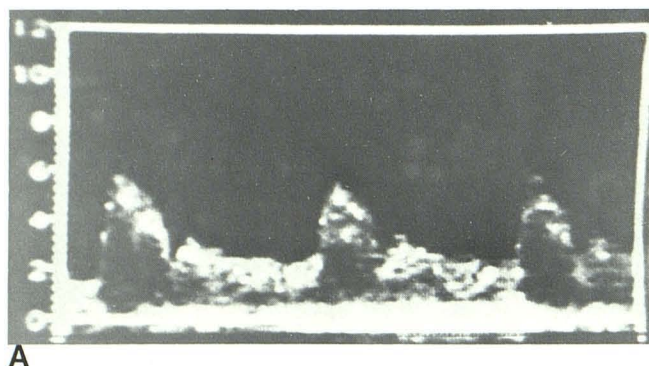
Severe stenosis with relatively normal signals. False-negative diagnosis of stenosis in 76-year-old man with numbness in left arm and leg and mild right facial paresis. No bruits were audible. A, Doppler examination. Slight frequency elevation in right internal carotid extended over fairly long segment and was attributed to minor stenosis. Minimal turbulent flow was heard in distal part of vessel. Right posterior orbital flow was normal in direction. B, Arteriogram. Severe, lengthy stenosis of internal carotid with diminished blood flow. Relative absence of poststenotic turbulence was attributed to reduced flow velocity. (Arteriogram courtesy of A. Yale Gerol, Kenosha, WI.)
